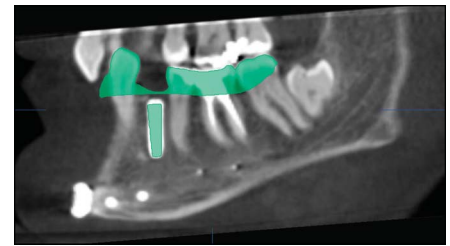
Screenshot from Brainlab showing the sagittal plane of a superimposed STL (green) and CBCT (gray) scan to examine the deviation between the planned (green) and achieved (gray) implant position. For precision, the deviation was then calculated with the exact 3-dimensional coordinates from apex and entry point from every planned and placed implant.
